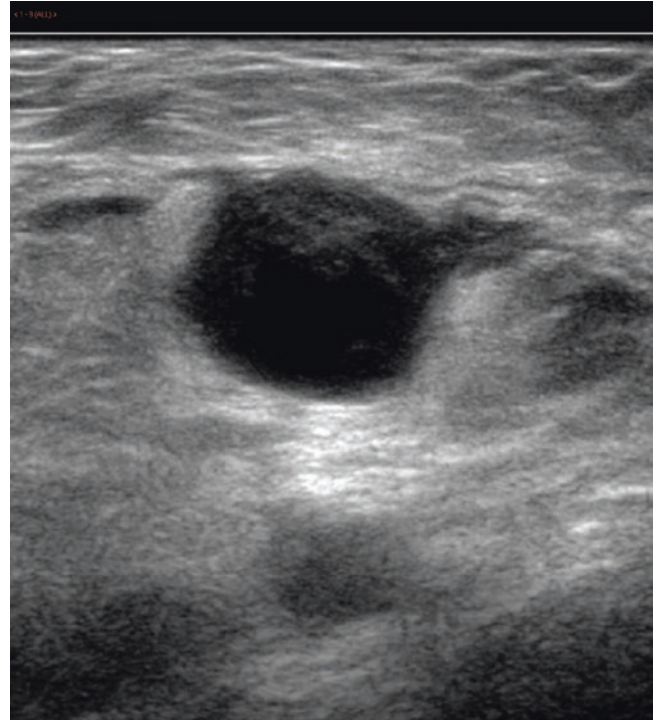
Ultrasound of the left groin in a child with groin swelling following cardiac catheterisation. Greyscale image shows focal dilatation at the left common femoral arterial puncture site
